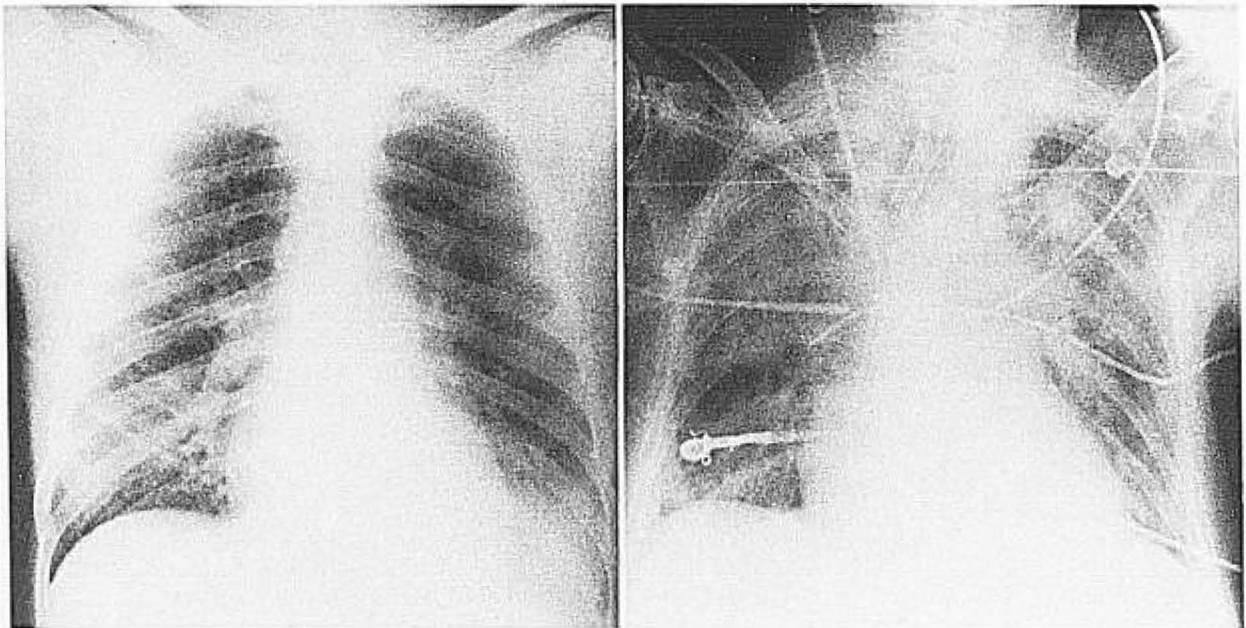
Influenza pneumonia. The radiograph on the left shows combined influenza pneumonia with left lower lobe consolidation indicating bacterial suprainfection. The radiograph on the right shows diffuse alveolar infiltrates in the course of serologically documented influenza A infection. Bacterial cultures from endotracheal secretions consistently showed no growth.
